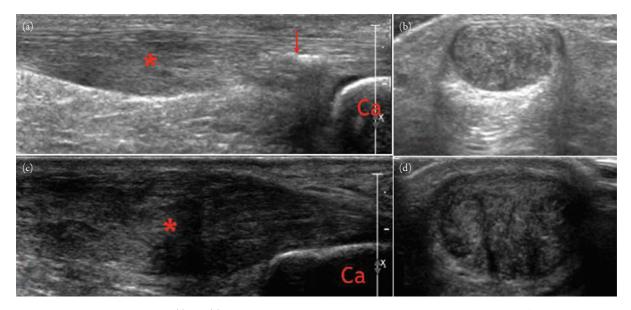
Achilles tendinopathy. Panels (a) and (b), respectively, show longitudinal and transverse ultrasound images of thickening and hypoechogenicity of the noninsertional segment of the Achilles tendon (*). Echogenic foci (arrow) with posterior acoustic shadowing in the Achilles tendon near the calcaneal (Ca) insertion represents dystrophic calcification. Panels (c) and (d), respectively, show images in longitudinal and transverse plane of a severely enlarged and hypoechoic Achilles tendon with loss of the normal fibrillar configuration of the tendon, which represents severe tendinopathy.
